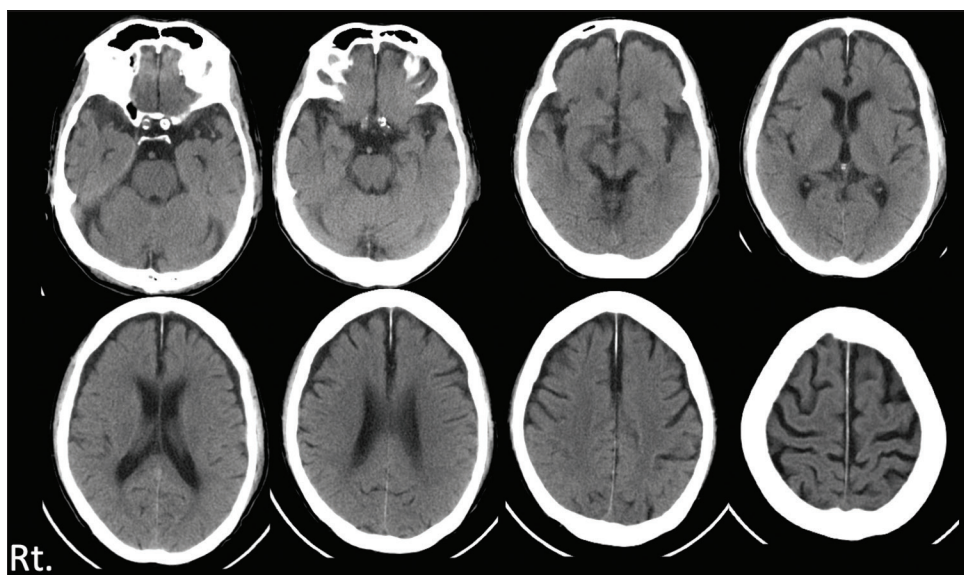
Initial head computed tomography revealed no hemorrhagic findings.
